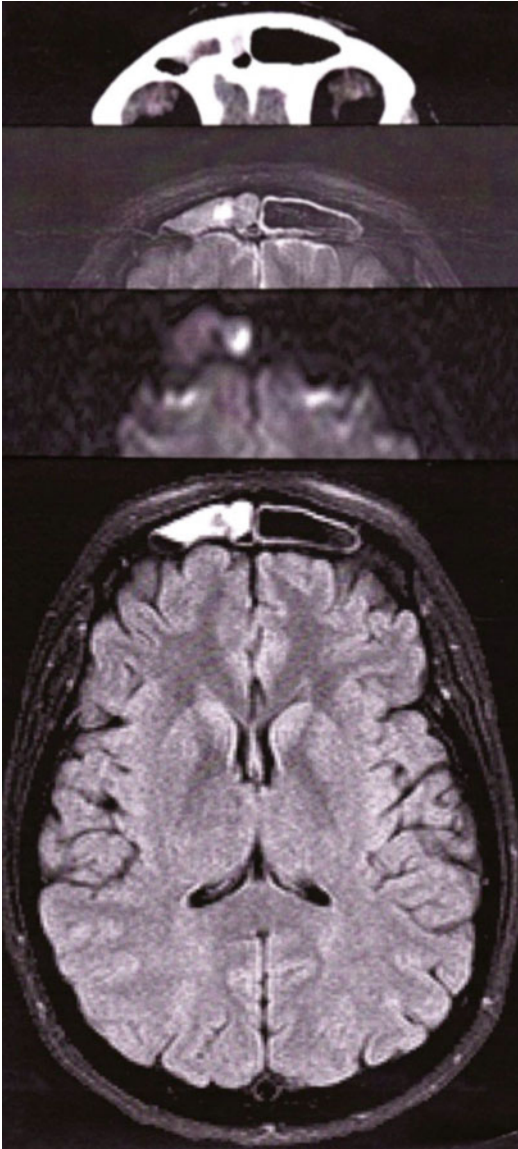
Frontal sinusitis mimicking subarachnoid hemorrhage with “worst headache ever” event with barotrauma while descending in an airplane about to land. *Top to bottom:* CT, T2, diffusion, FLAIR
